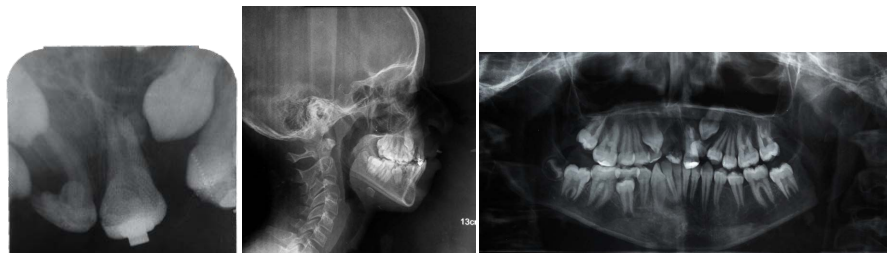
Occlusal bite, tele-profile, and Panoramic X-rays before treatment.
